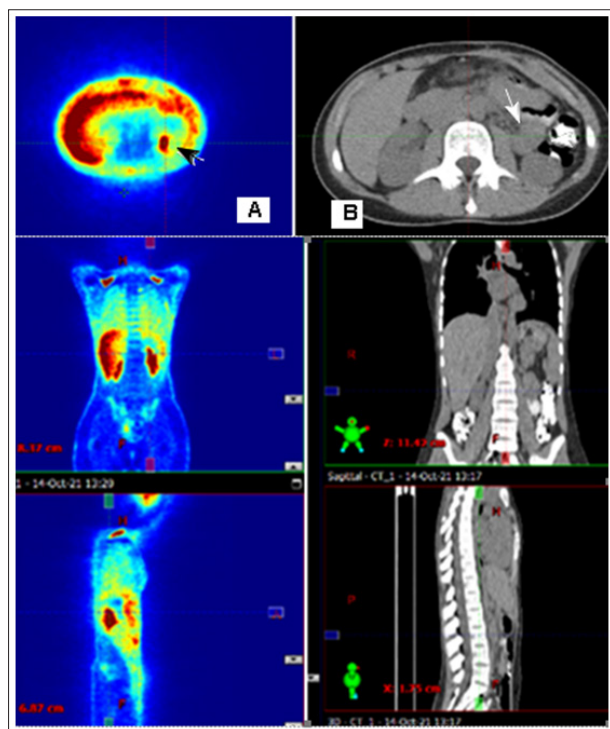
FDG PET/CT October 2021- A/ Dorsal between the spleen and the upper third of the left kidney is again depicted with a soft tissue lesion with the radio marker's supply fixation. The transitional described soft tissue lesion adjacent to the upper left kidney's upper pole has reduced metabolic activity SUVmax 6.06 (before SUVmax 9.73) with a local recurrence characteristic. The black arrow shows this formation. B/ CT image of the soft tissue recurrent lesion which is shown with a white arrow.
